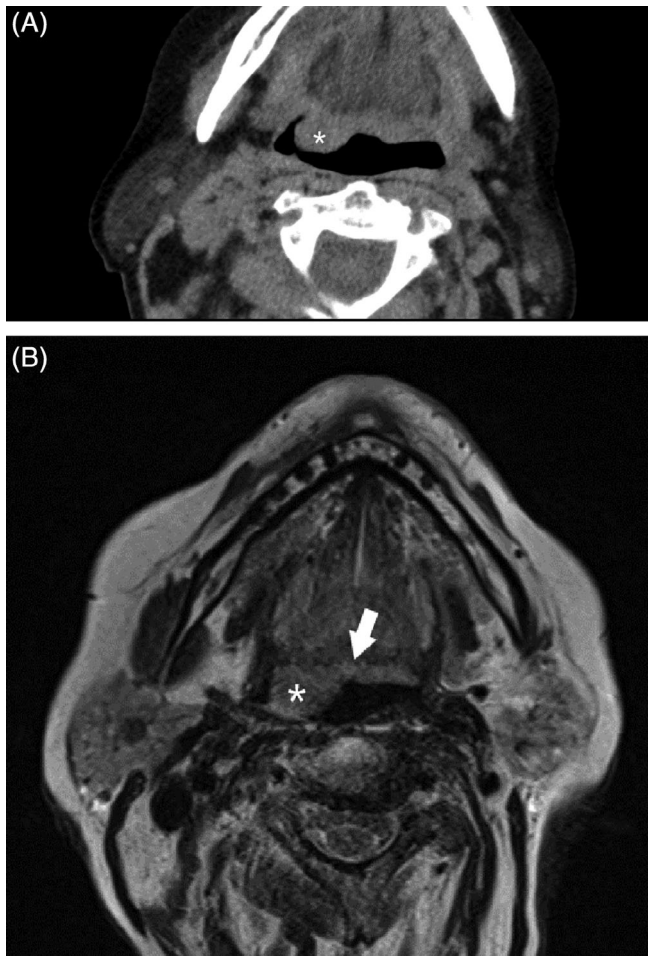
CT and MR images demonstrate candidates for transoral robotic surgery in patients with tongue base primary carcinoma. A, Axial contrast-enhanced CT image demonstrates right-sided exophytic tongue base mass (*) with no signs of deep invasion. B, Axial T2-weighted MR image demonstrates right tongue base mass (*) which extends towards the midline (white arrow) of the tongue. Limited bilateral tongue base lesions are still candidates for resection
